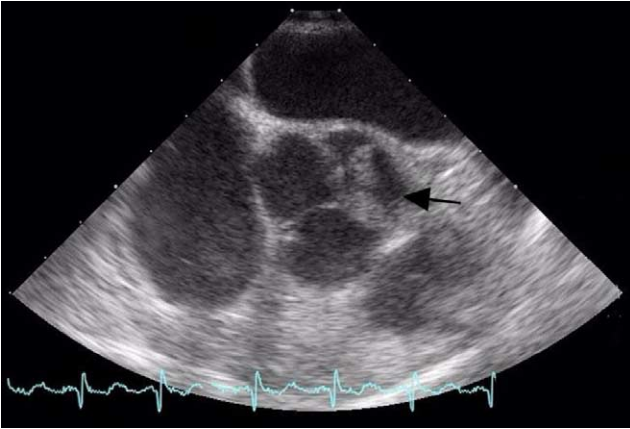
Transesophageal echocardiography. Anechoic lesion at the right and left cusp coronary junctions.
